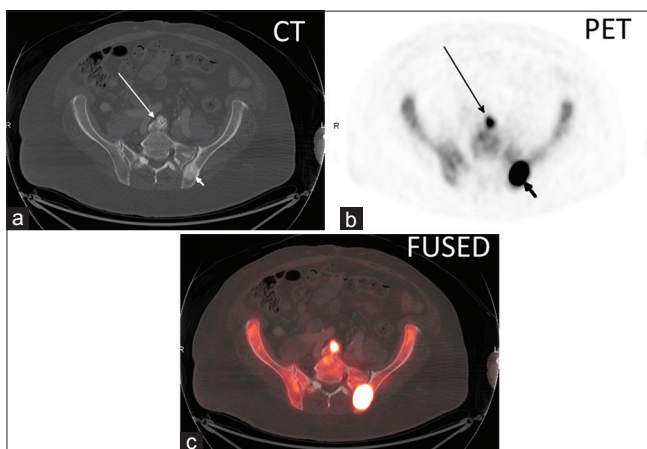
(a) Axial CT, (b) axial ^{18}F NaF PET, and (c) axial fused PET/CT image in a lumbar spine degenerative disc osteophyte (long arrow) with a SUV_{max} of 20.7 and in a left posterior iliac bone sclerotic metastasis (short arrow) with a SUV_{max} of 101.5
